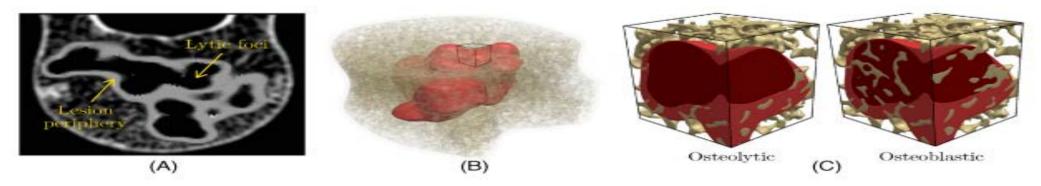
(A) Co-registered CT-MRI scan of a vertebra with a metastatic tumor; (B) 3D reconstruction of tumor morphology added to the virtual vertebral model generated using ReconGAN; (C) comparing lytic and blastic tumors in a small portion of the trabecular bone
